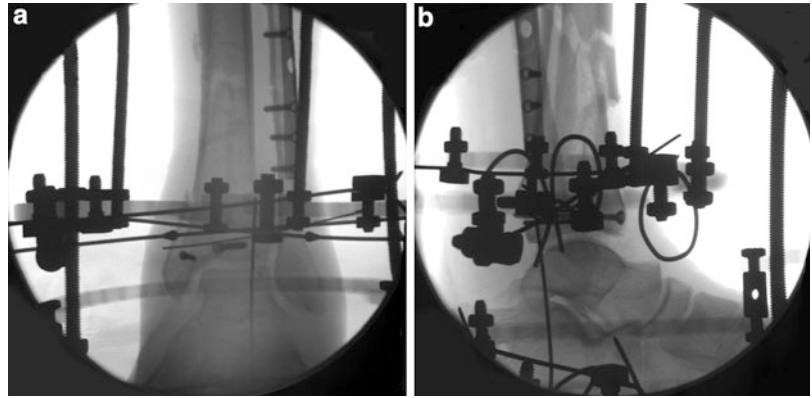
(a–c) Post-operative X-rays of pilon fracture reconstruction. Clinical photograph of similar frame. Notice the half ring off set with two centimeter sockets closing the foot ring to increase ring stiffness. The Steinman pin fixating the posterior fragment is left in place for 6 weeks
